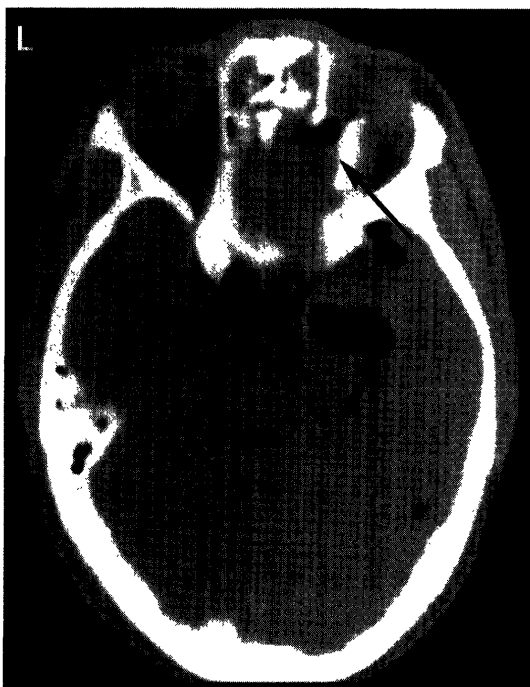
CT scan demonstrating the fracture of the medial wall of the orbit. Air collection is noted in the vicinity of this fracture (*arrow*). It is difficult to ascertain whether the air is intracerebral, subdural, or subarachnoid. Subarachnoid (*arrowhead*) and intraventricular (*curved arrow*) air pockets are also demonstrated.
